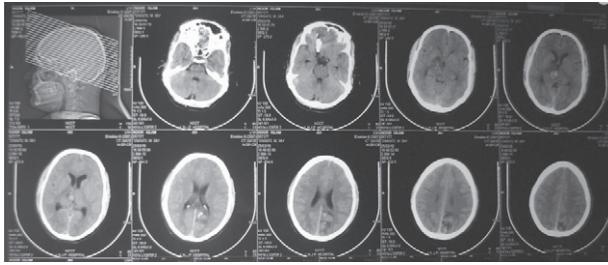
Post operative CT scan brain
